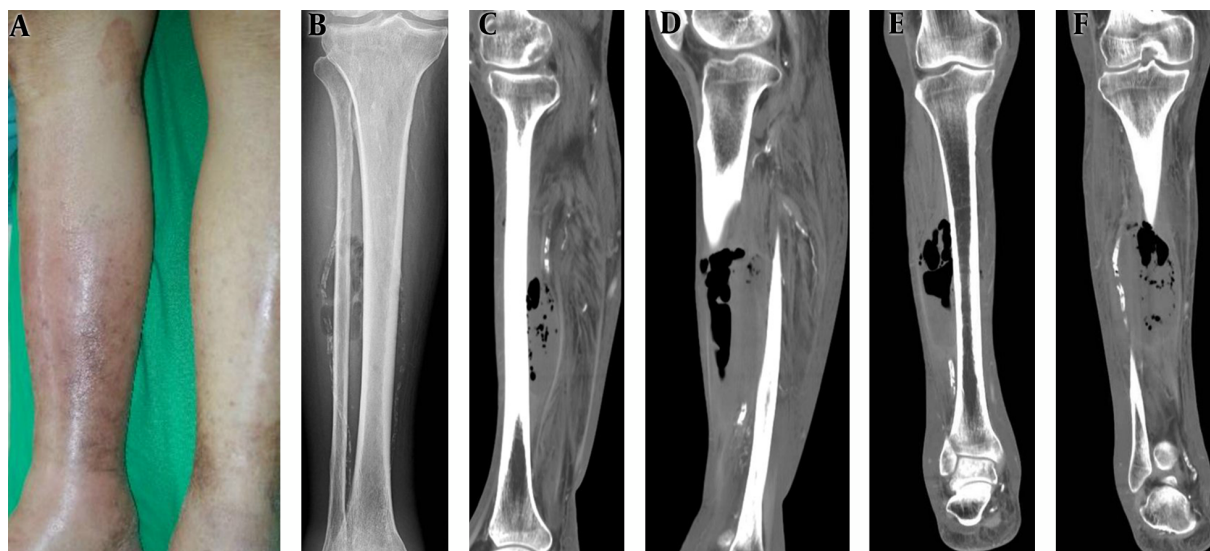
Necrotizing fasciitis of gross picture, plain X ray and computed tomography
